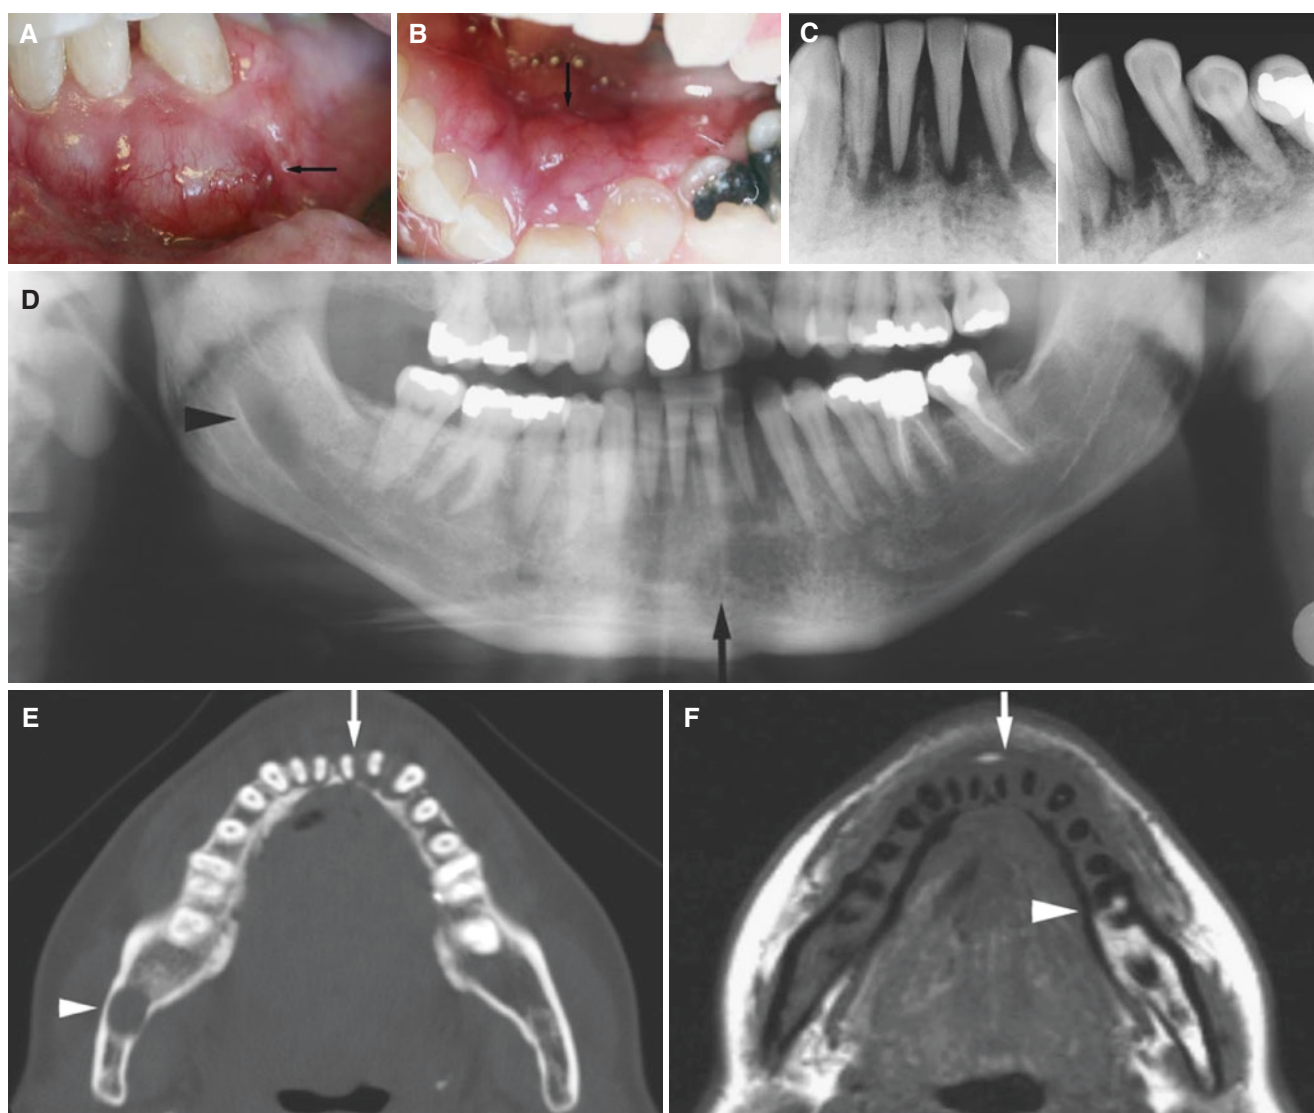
Adenoid cystic carcinoma, mandible; 43-year-old female with loose anterior teeth and hard gingival swelling. (A) Clinical photograph shows buccal swelling with normal mucosa (*arrow*). (B) Clinical photograph shows lingual swelling with normal mucosa (*arrow*). (C) Intraoral views show ill-defined bone destruction around several teeth. (D) Panoramic view shows destruction around anterior teeth (*arrow*) and widened mandibular canal (*arrowhead*). (E) Axial CT image shows bone destruction around anterior teeth (*arrow*) and widened mandibular canal (*arrowhead*). (F) Axial T1-weighted pre-Gd MRI shows cortical bone destruction (*arrow*) and reduced signal from marrow in the entire mandible to molar region on the left side (*arrowhead*). (G) Axial
